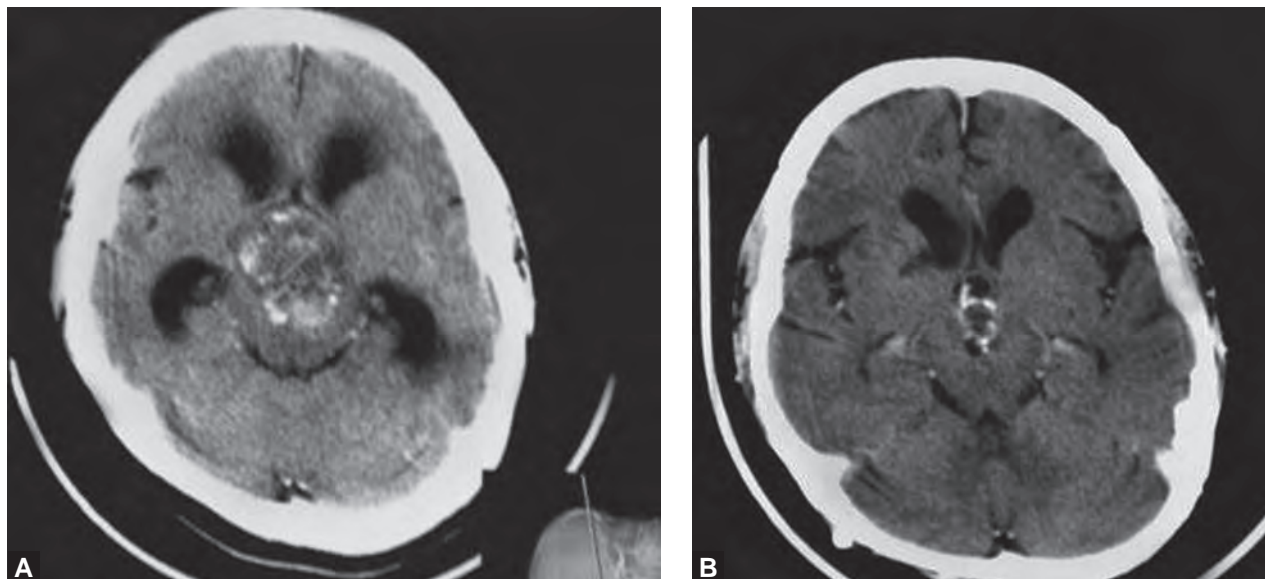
(A) CT scan showing residual lesion in a boy of 10 years.
